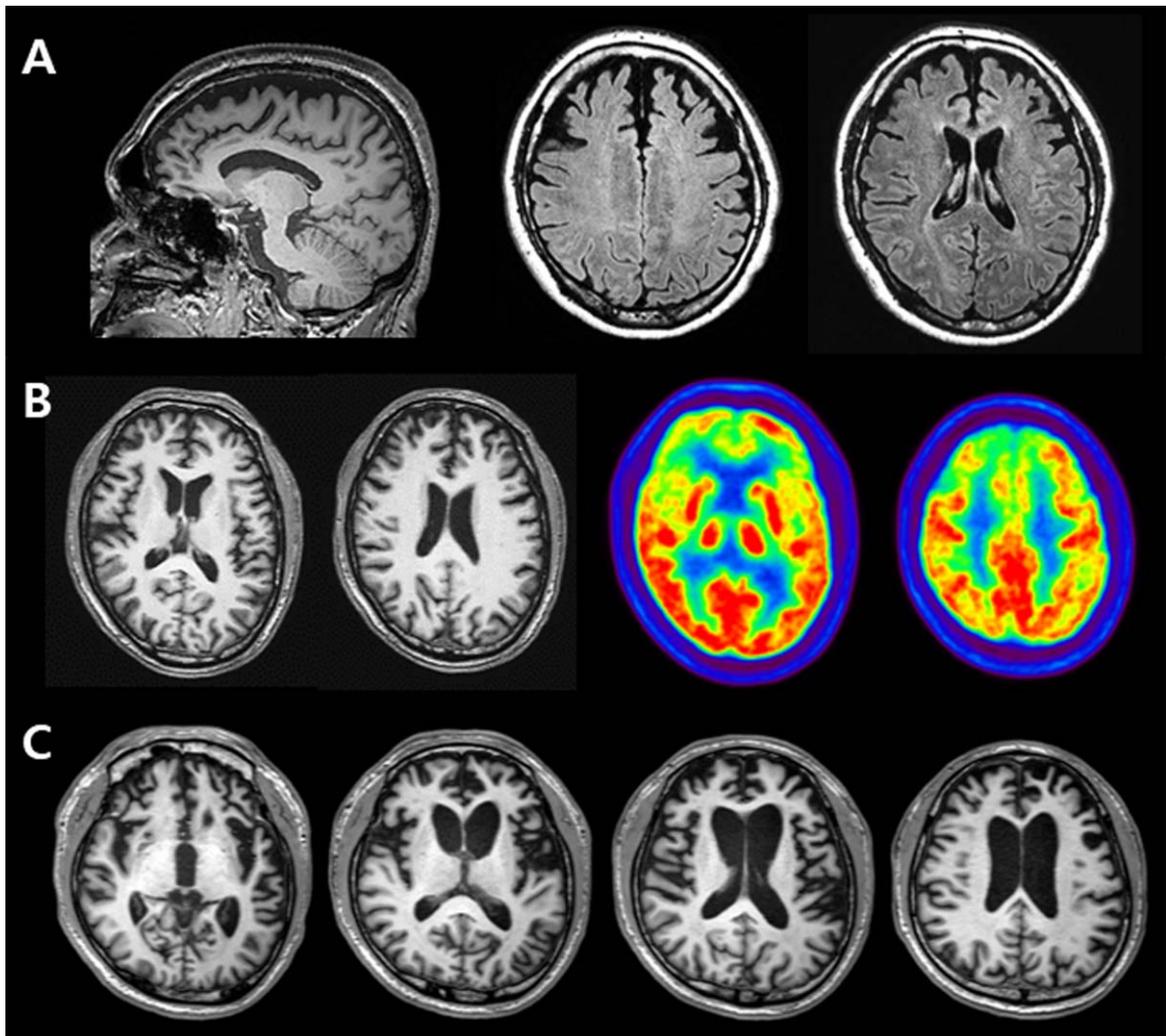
A) Brain MRIs of FTD-18 who carried variant p.G706R of the *MAPT* gene, revealing bilateral and symmetric frontal atrophy. B) Brain MRIs and FDG-PET images of FTD-13 who carried variant M232R of the *PRNP* gene, showing cortical atrophy and severe glucose hypometabolism in the bifrontal areas. C) Brain MRIs of FTD-39 who carried variant M232R of the *PRNP* gene, demonstrating prominent bilateral frontotemporal atrophy, worse on the left.
